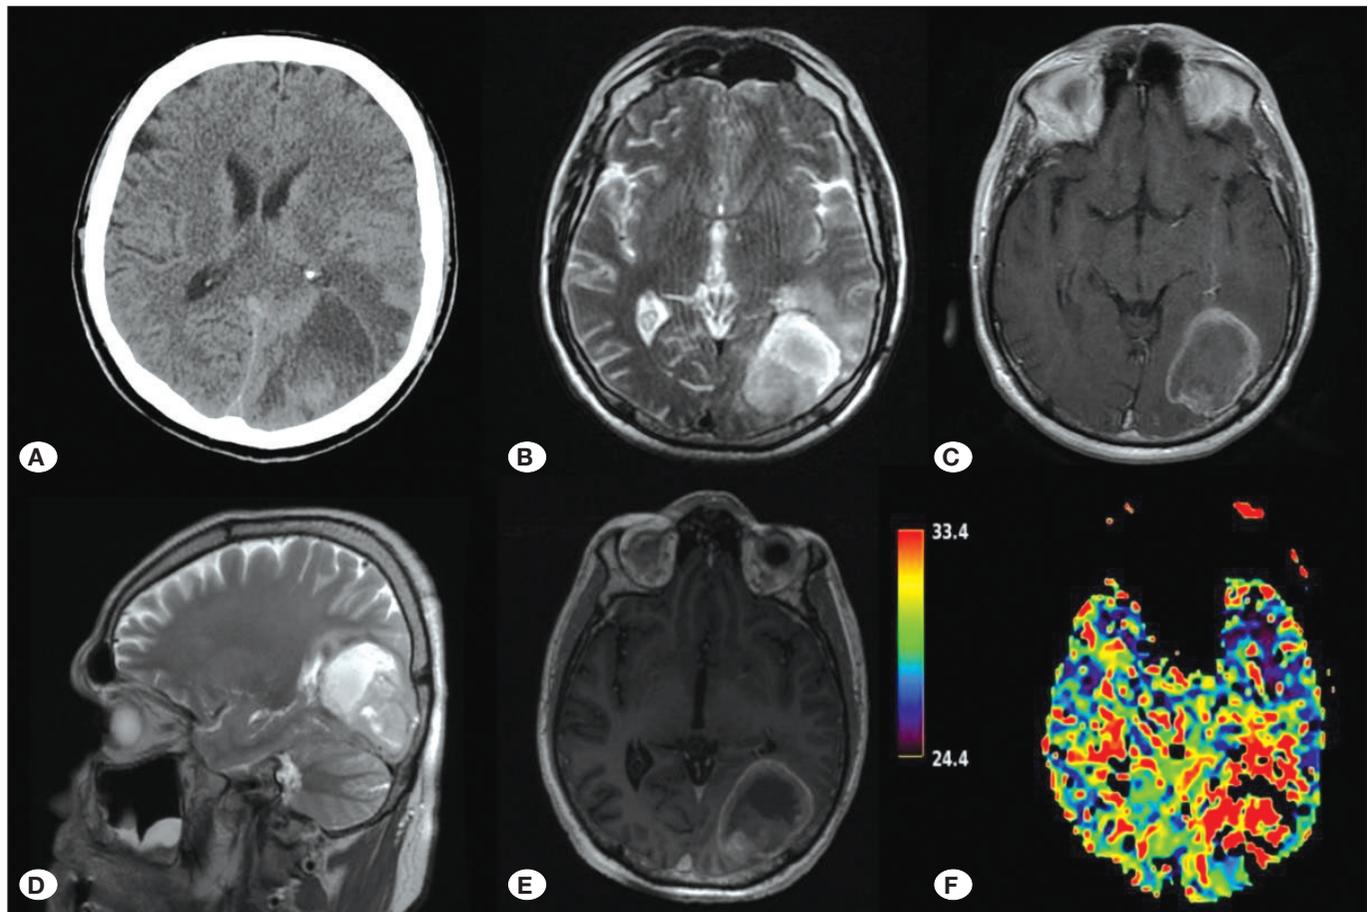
A) Axial CCT, B) axial T2W MRI of the brain, C) contrast enhanced T1W axial brain MRI, D) T1W sagittal MRI of the brain on 15th day, E) contrast enhanced T1W axial MRI of the brain on 15th day, F) perfusion weighted MRI on 15th day.
